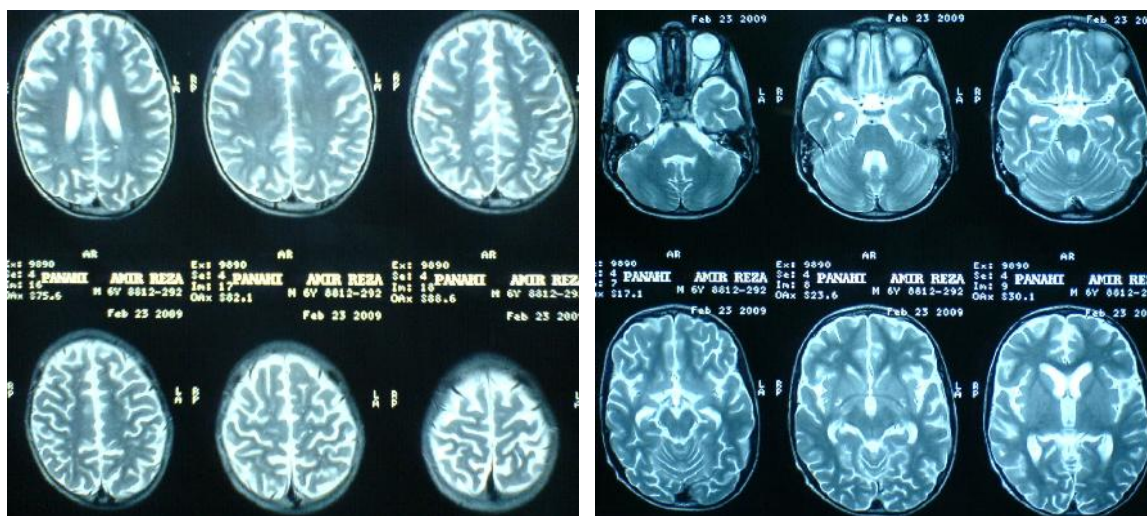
Brain MRI shows multiple hyperintense images as diffuse subcortical demyelinating areas especially in posterior occipital lobes
